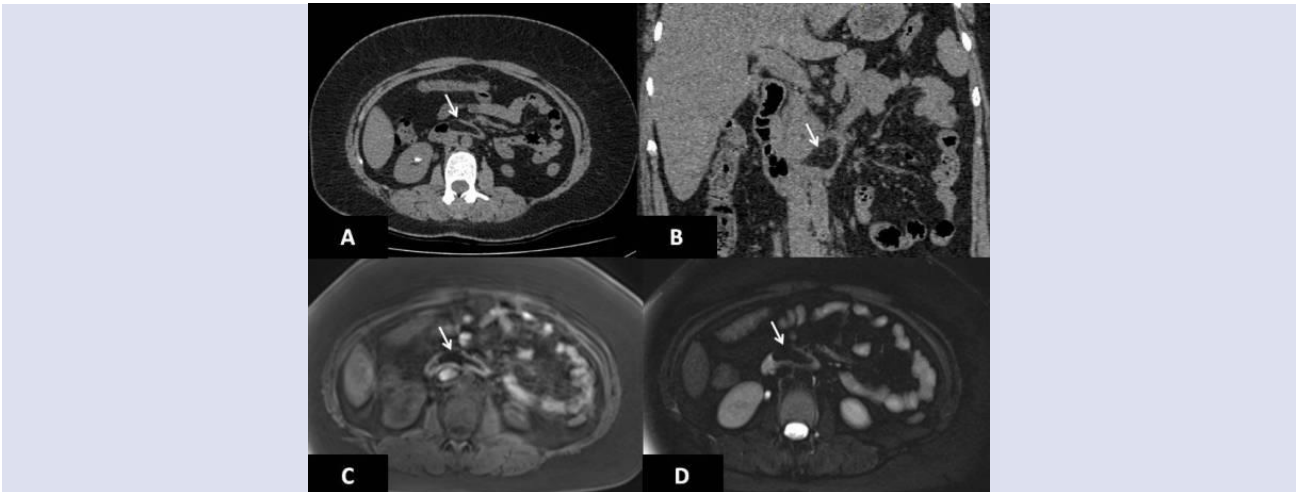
(A) Axial and (B) coronal abdominal CT images show a smooth-walled, fat density mass in the third portion of the duodenum (arrows). Axial fat-suppressed (C) T1-weighted and (D) T2-weighted images demonstrate a well-defined, hypointense, oval lesion in the third portion of the duodenum (arrows).
